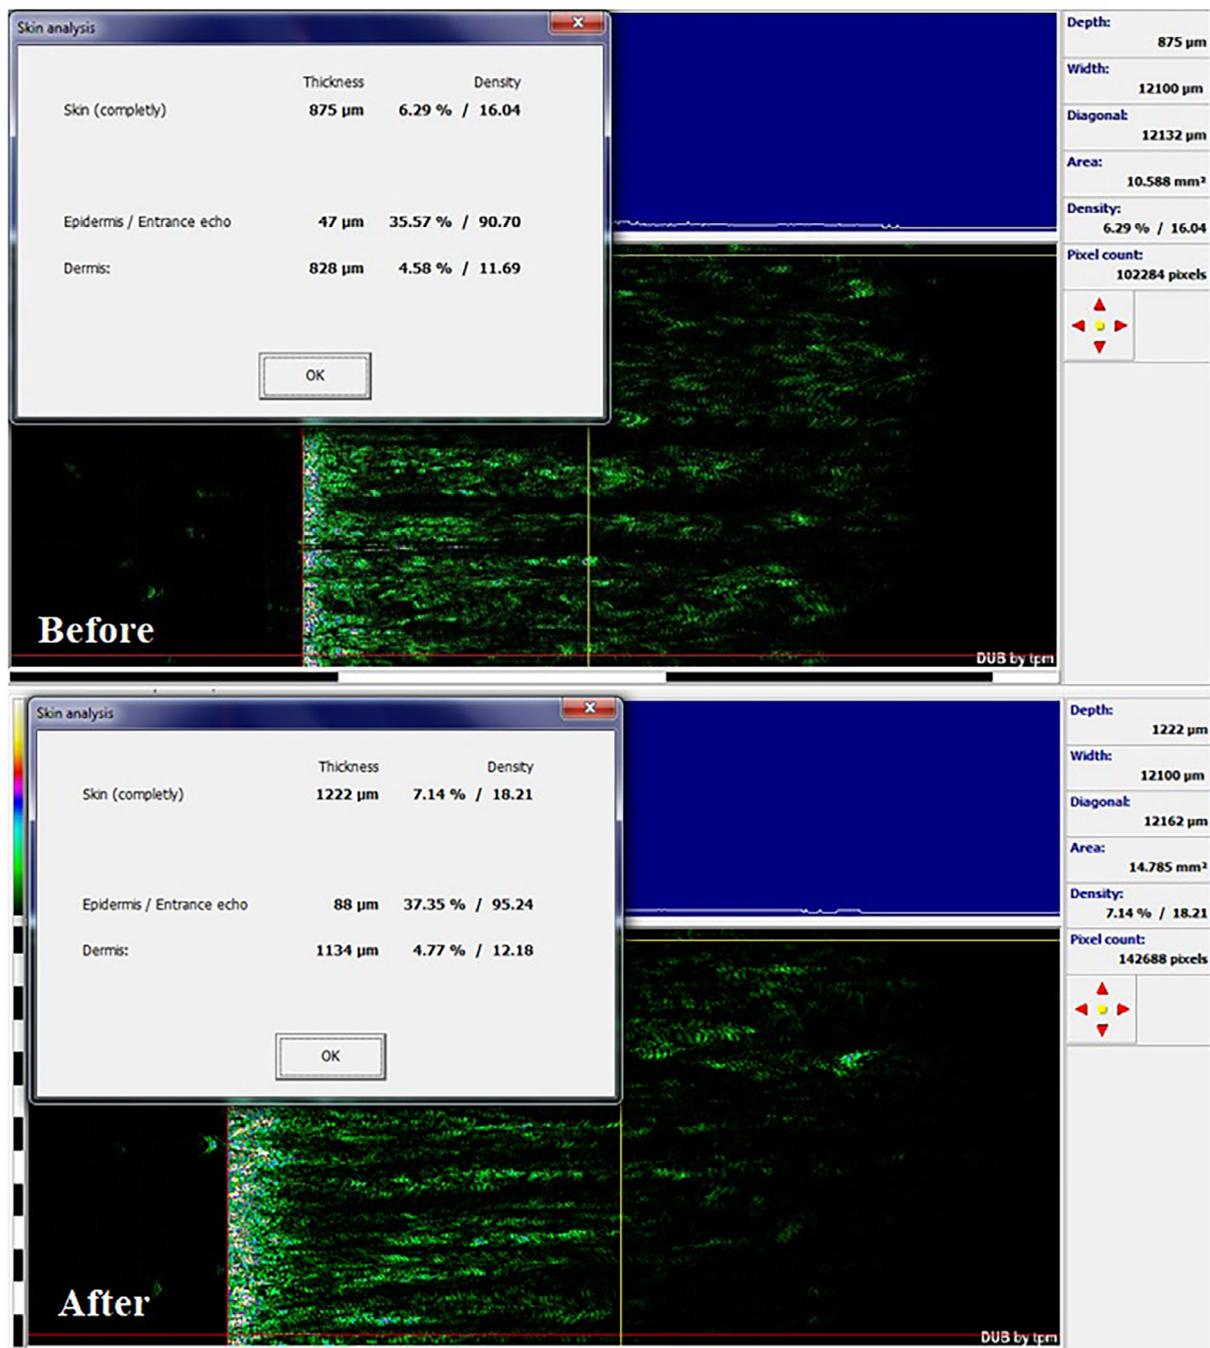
Skin analysis with ultrasonography for case B.
